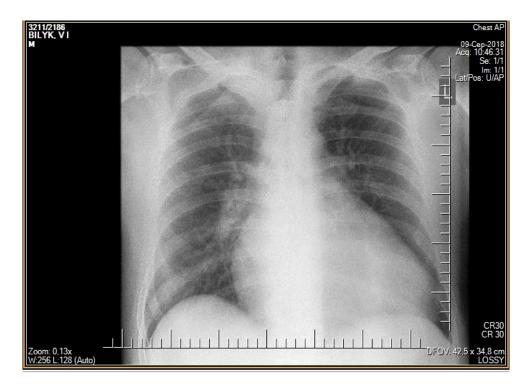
X-ray examination of the thoracic cavity organs
